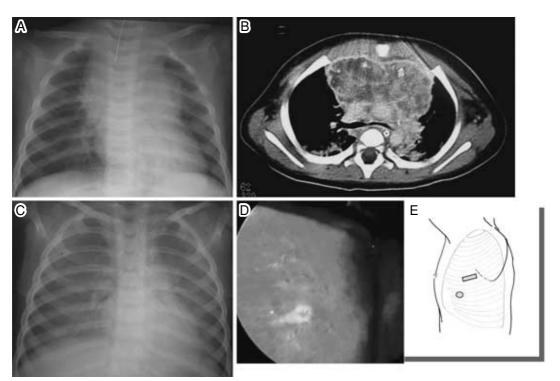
Patient 2. Lung biopsy for lymphoid interstitial pneumonia after chemotherapy A, chest radiography before chemotherapy for mediastinal Langerhans' cell histiocytosis; B, chest CT before chemotherapy; C, chest radiography showing diffuse reticular shadow 9 months after chemotherapy; D, thoracoscopic view of the left lung; E, position of minithoracotomy and a trocar port.
